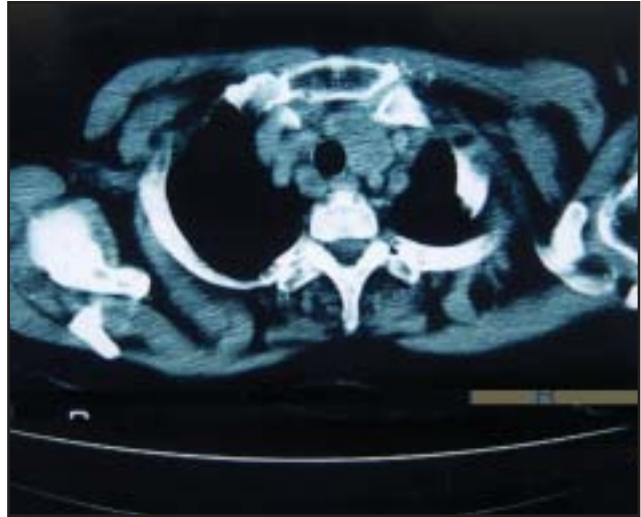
CT scan of the patient's neck.
